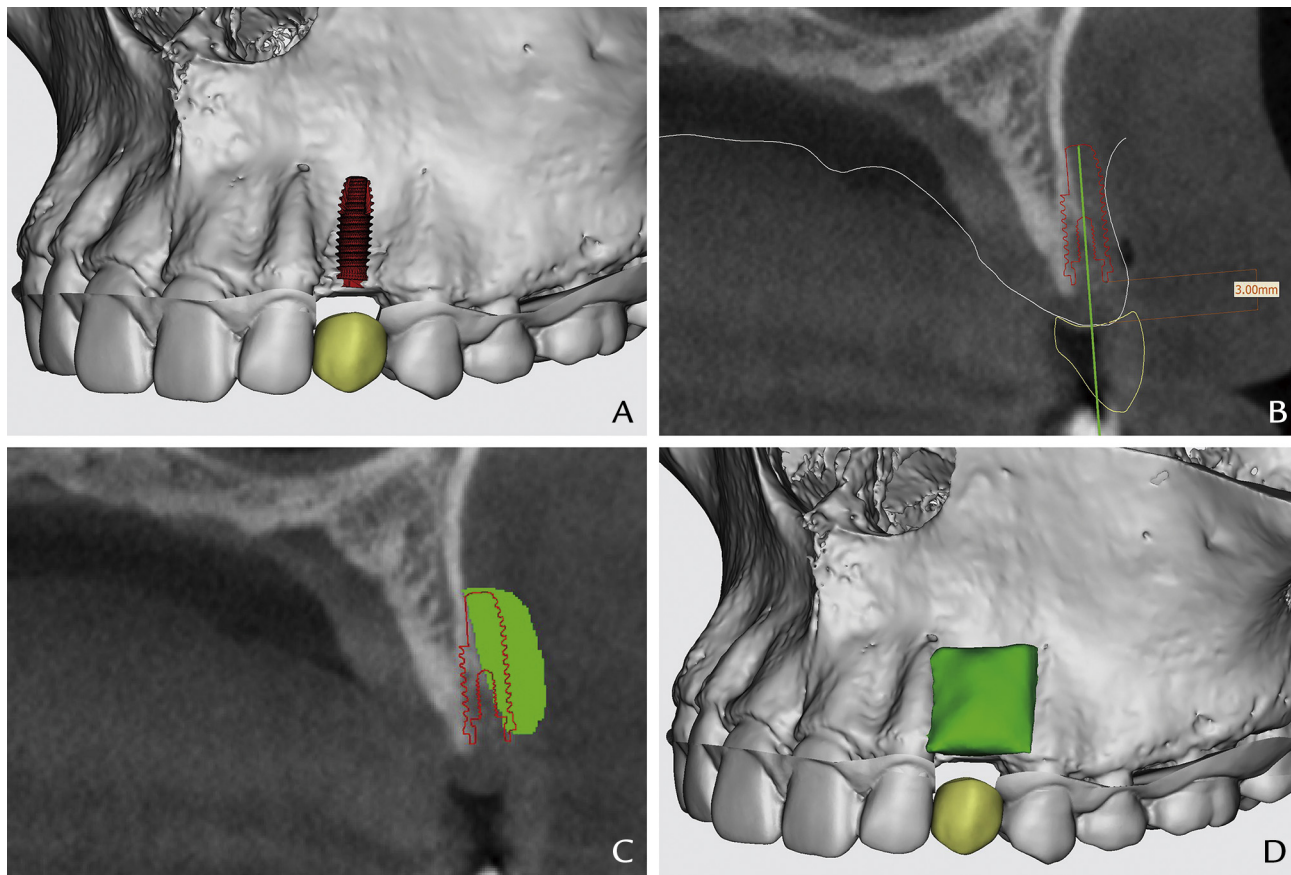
Design of definitive prosthesis, implant, and graft. A, Dentition scan model superimposed onto 3-dimensional reconstructed maxilla. Definitive prosthesis (yellow) and definitive implant (red) planned. B, Planned prosthesis (yellow) and implant (red) on cone beam computed tomography. C, Virtual plan of bone block graft (green). D, Virtual plan of bone block graft (green).
